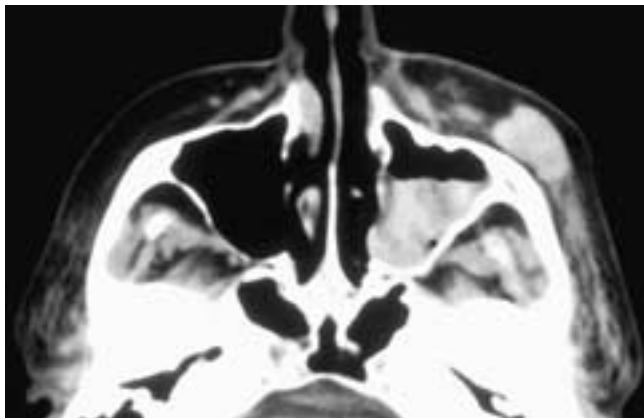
Axial CT scan shows a soft-tissue density in the subcutaneous tissues of the left facial area representing hematoma. There are also edematous changes in the adjacent soft tissues due to edema. There is dense fluid in the left maxillary sinus. This patient fell and developed a hematoma and edema in the left face with hemorrhage in the left antrum.
